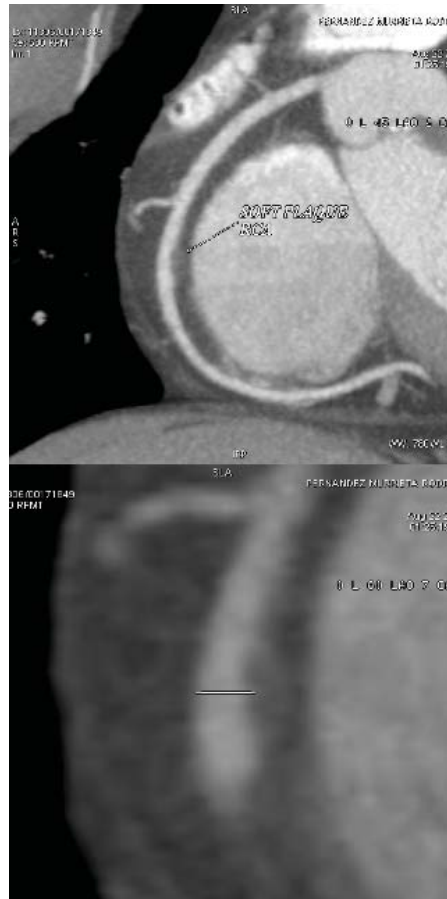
CT images of vulnerable plaque in 28-year-old patient with atypical chest pain and strong family history of heart disease at early ages.
